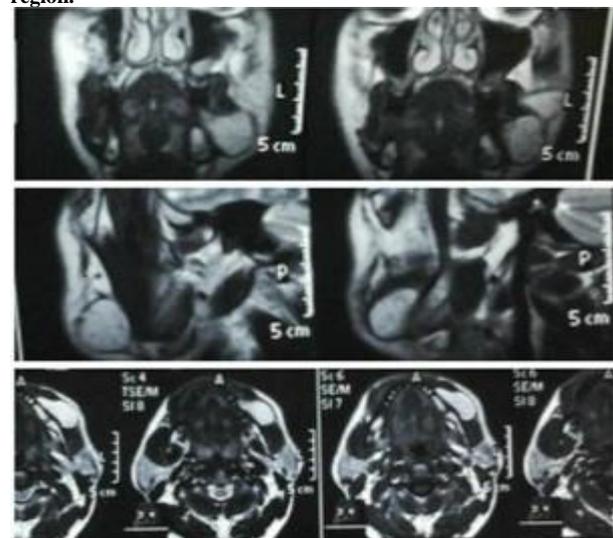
MRI in different sections show :
